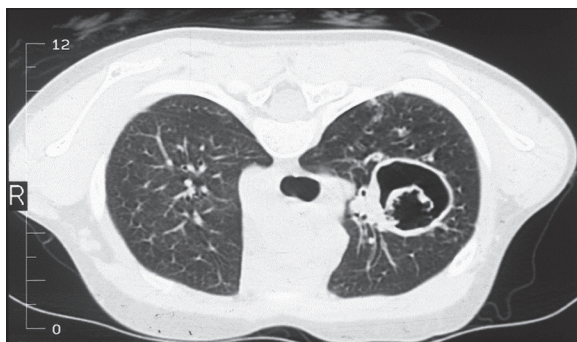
Axial CT scan of the chest, pulmonary window. Inflammatory cyst in the upper lobe of the left lung complicated by fungal infection.
